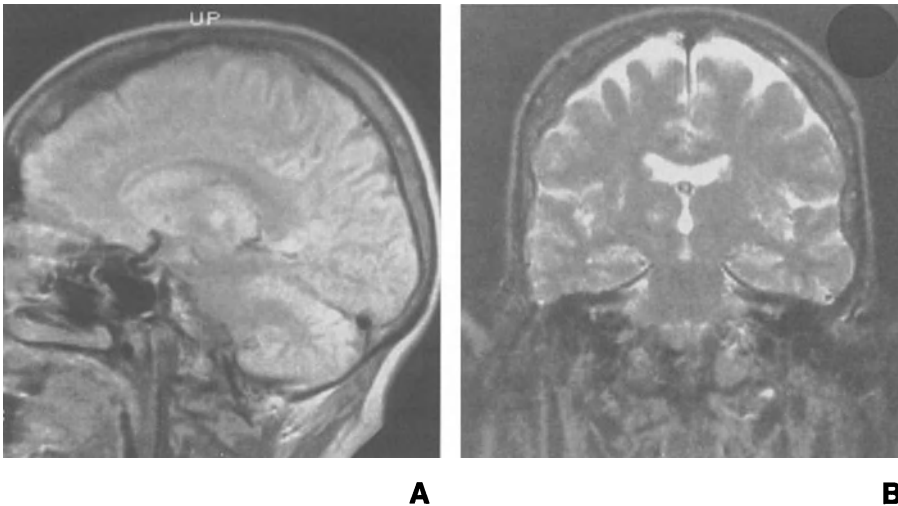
Right thalamotomy, (A) coronal and (B) sagittal T2-weighted MRI images from a patient treated by right-sided Gamma Knife thalamotomy 3 months earlier. Note bright signal area in the right thalamus
